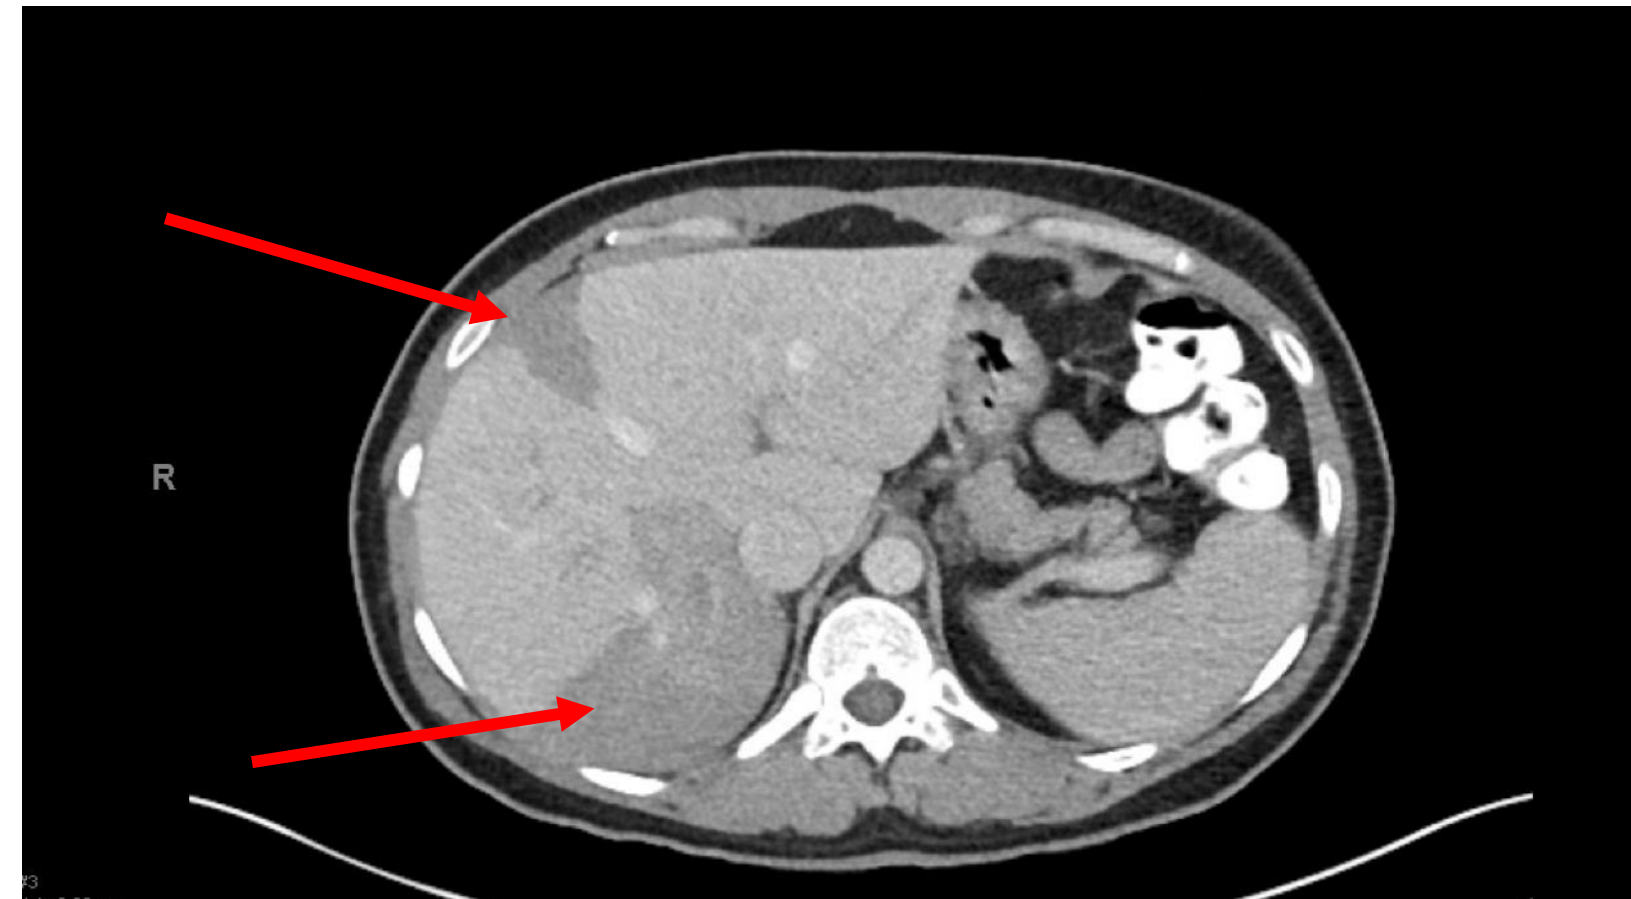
CT scan image displaying large, peripheral, wedge-shaped areas of hypoattenuation and hypoenhancement in the liver.
